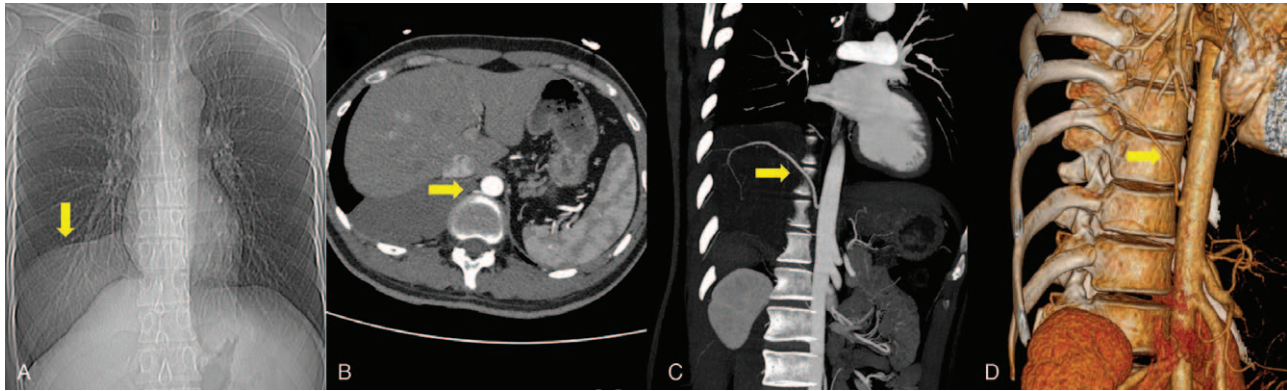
The images of the intrathoracic lesion (indicated by arrows). A. The x-ray in August 2019 showed an intrathoracic lesion. B. The blood supply of the lesion from the adjacent descending thoracic aorta. C and D. Preoperative 3D-CTA confirmed the feeding vessel of the sequestered lobe.
